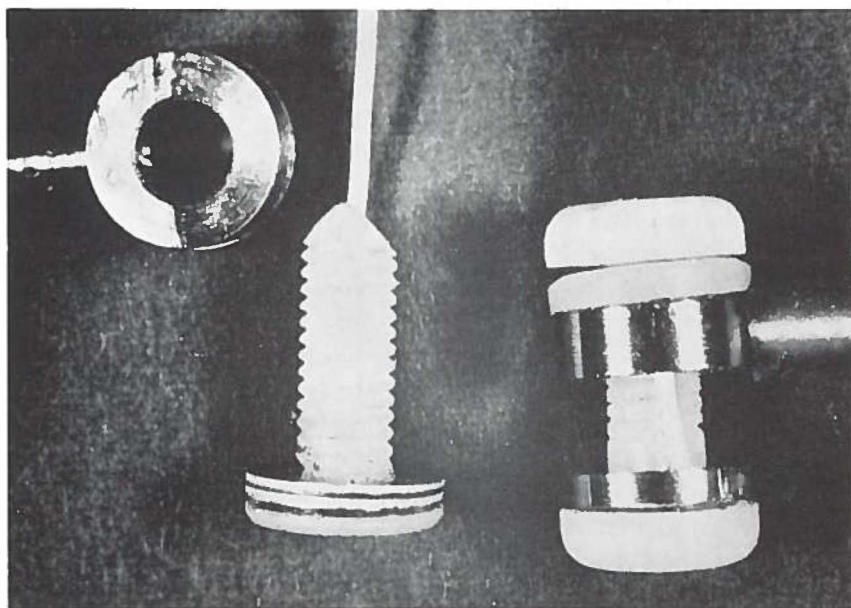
Transthoracic endocardial electrode with epicardial plate.
